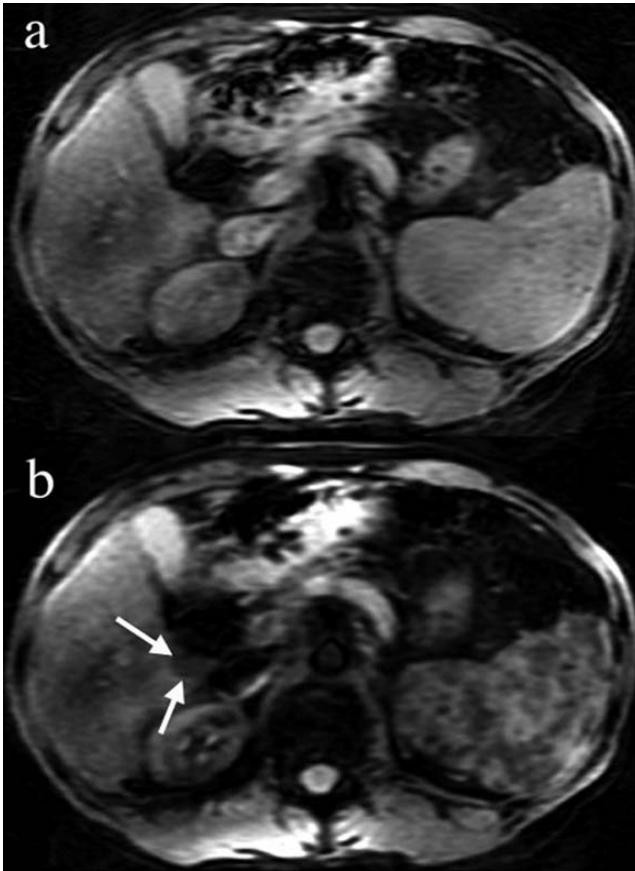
HCC in a 58-year-old male. Perfusion MR imaging. With use of the parallel imaging technique, the image quality of single-shot echo planar imaging is improved. The tumor in S6 becomes low in signal intensity following bolus injection of SPIO (arrows). Imaging parameters are as follows: spin echo type echo planar imaging; Repetition time (TR) = 4000 msec (millisecond), TE = 58 msec (millisecond), b-value = 500 s/mm², number of excitation = 8, matrix size = 128 × 128, slice thickness = 7 mm, parallel imaging factor = 2.
